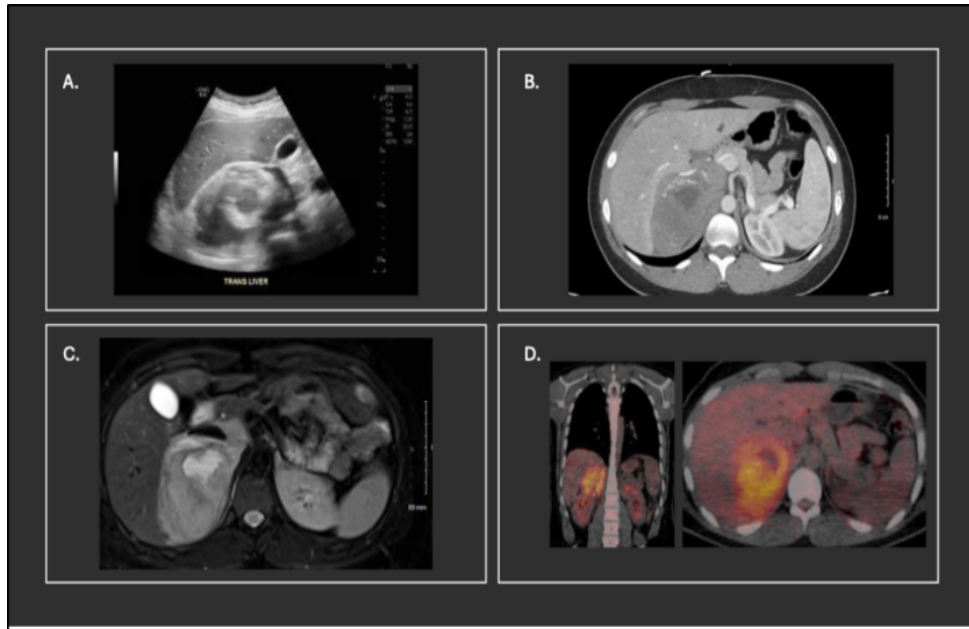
Multimodal Imaging of Adrenal Lesion. (A) Ultrasound: 12.3 x 9.9 x 7.8 cm heterogeneous mass in Morrison's pouch, inseparable from the right kidney and liver. (B) CT: 10 cm calcified adrenal mass adherent to the liver, IVC, diaphragm, with bulky retroperitoneal lymphadenopathy. (C) MRI: Hyperintense adrenal mass on T2-weighted imaging with regional lymphadenopathy. (D) FDG PET: Partially necrotic, FDG-avid adrenal mass with retroperitoneal lymph node involvement; no distant disease. This imaging highlights tumor size, spread, and metabolic activity for clinical management.
